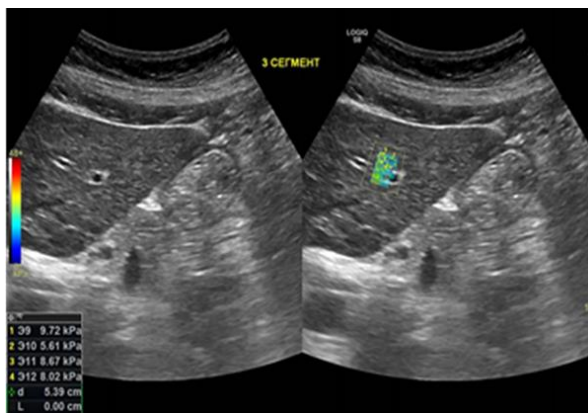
Ultrasound images of the liver parenchyma in the stage of fibrosis F3 according to METAVIR. 2D SWE values: 10.2 kPa, shear wave velocity 4.8 m/s.
